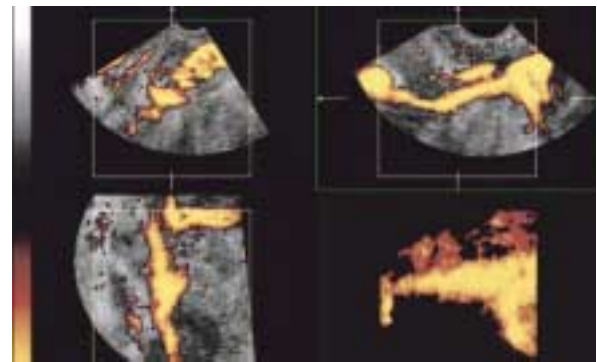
Three-dimensional ultrasound screen. Within the scanned volume, three matched and dynamically linked orthogonal sector planes are displayed simultaneously. The Fallopian tube's entire length, particularly the ampullary part, and free spill, are visualized. The color rendering allows further detailed assessment of the Fallopian tube.
